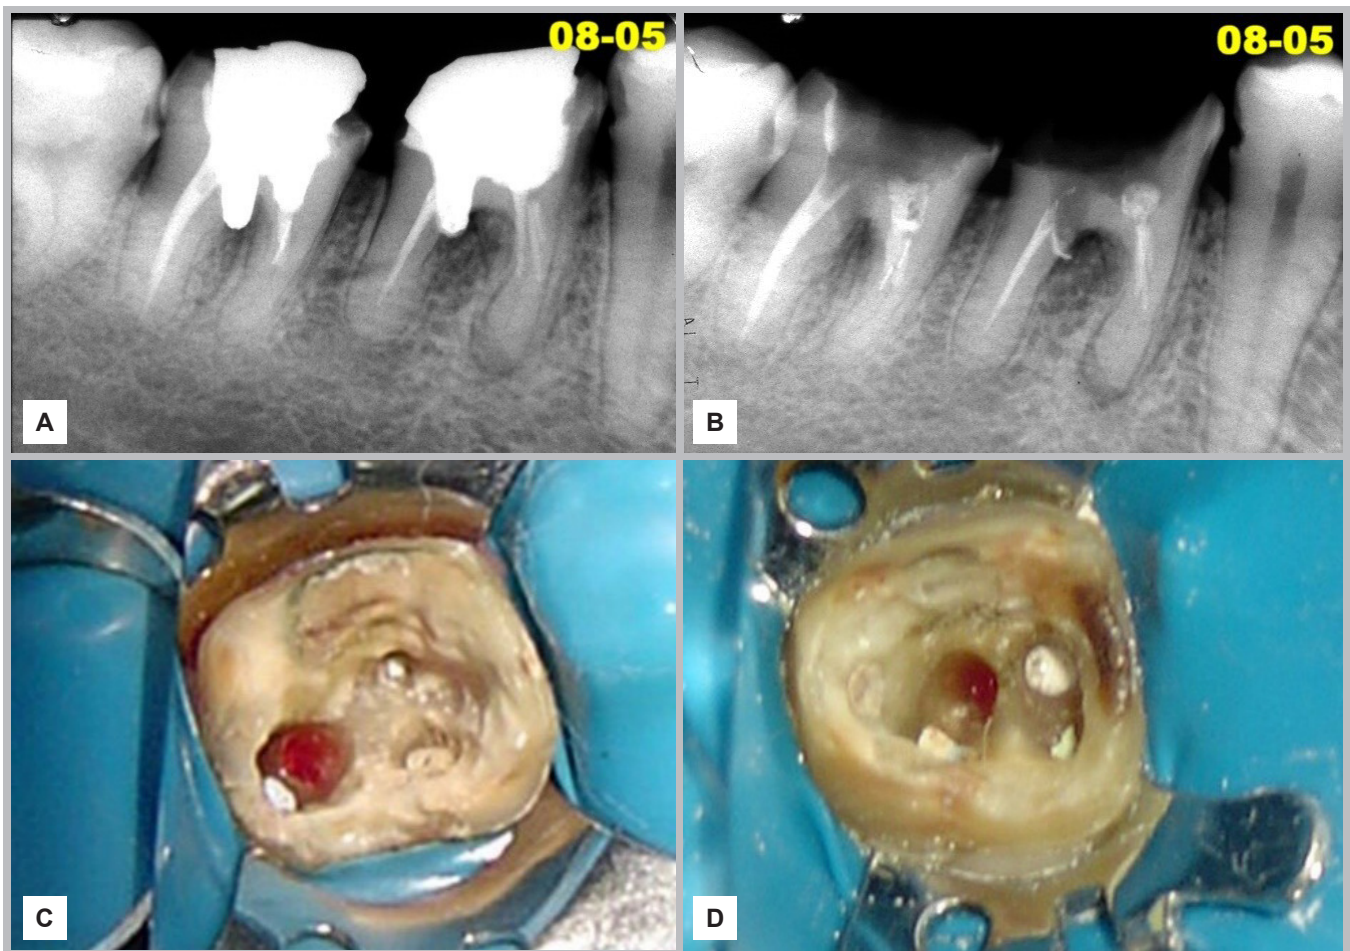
A) Teeth 46 and 47: diagnostic radiographic image. B) Teeth 46 & 47: removal of metallic posts. C) Tooth 47: photograph showing a 4-mm pulp chamber floor perforation. D) Tooth 46: photograph showing a 3-mm pulp chamber floor perforation.
